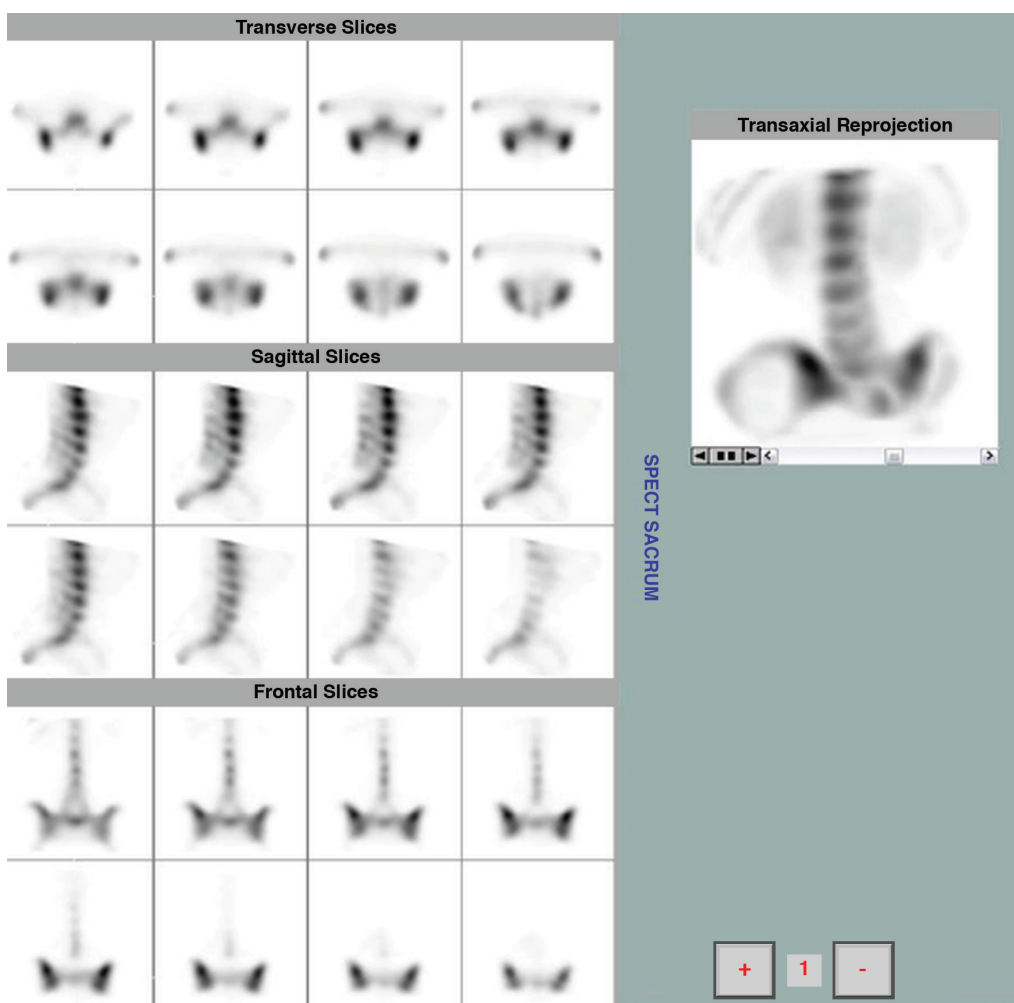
Absence of focal radiopharmaceutical uptake at the lower part of the sacroiliac joints (synovial part), excluding the presence of active sacroiliitis in a patient with negative magnetic resonance imaging findings
